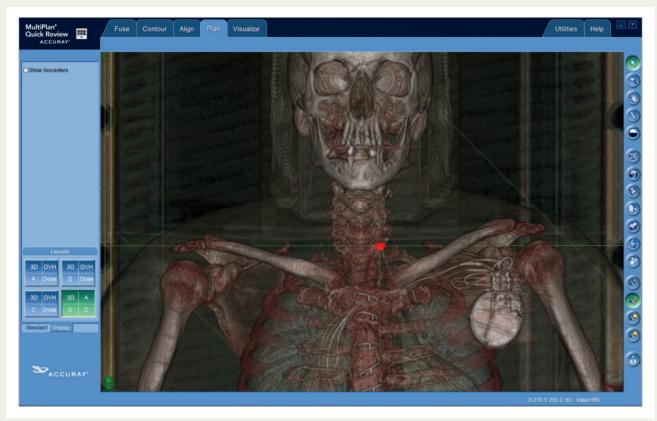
Computed tomography imaging of the left stellate ganglion—3D reconstruction.
